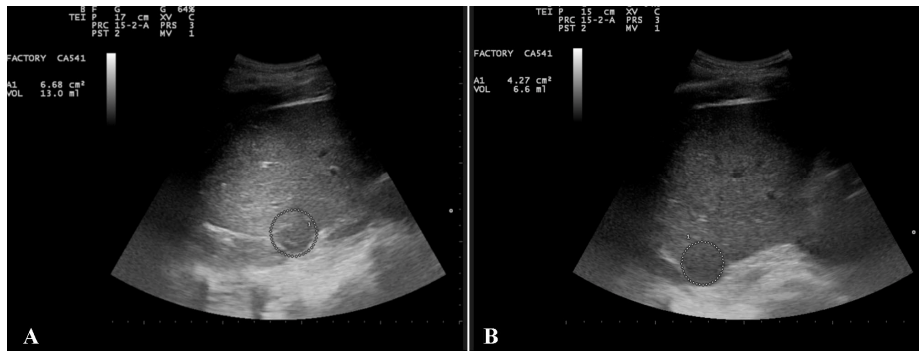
Ultrasonography of liver metastasis. A 63-year-old woman was diagnosed with colon cancer in 1997. A CT scan performed in April 2013 had confirmed metastases in lung and liver. After 2 weeks of integrative immunotherapy where OA-GcMAF (880 ng/day) was administered by alternating nebulisation and intramuscular injections, the lesion at the level of the liver showed a decrease of calculated volume from 13 ml (panel A) to 6.6 mL (panel B). This corresponds to approximately a 50% overall reduction
